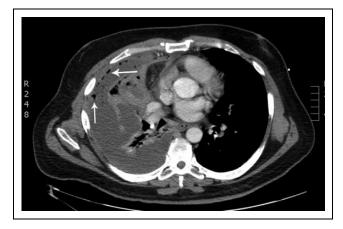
Chest computed tomography (CT) with intravenous contrast showing a loculated pleural effusion with internal pockets of gas (arrows).
